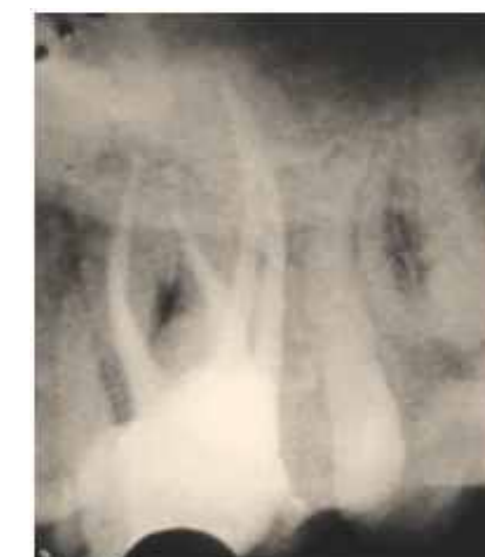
4 - Post- obturation Radiograph of 16
